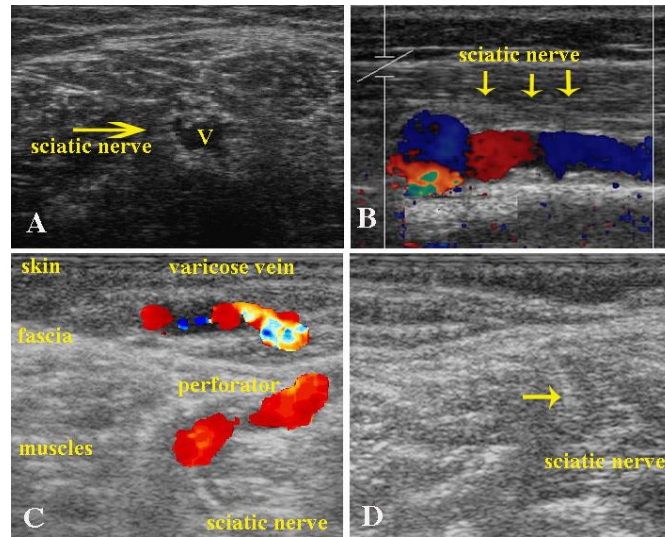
Sciatic nerve varices and its therapy by echo-guided sclerotherapy. The sciatic veins are deep veins and lay within the sciatic nerve. The nerve was easily visible on ultrasound imaging because of thickening of the neural sheath and dissection of the nerve fibres by the dilated vessels (Fig. A transversal access, B longitudinal access. C varicose veins of the lateral aspect of the leg fed by reflux coming from sciatic veins through a perforator. Please note in D) the echo coming from the foam reaching its target in an area not so easily reachable by surgery.
